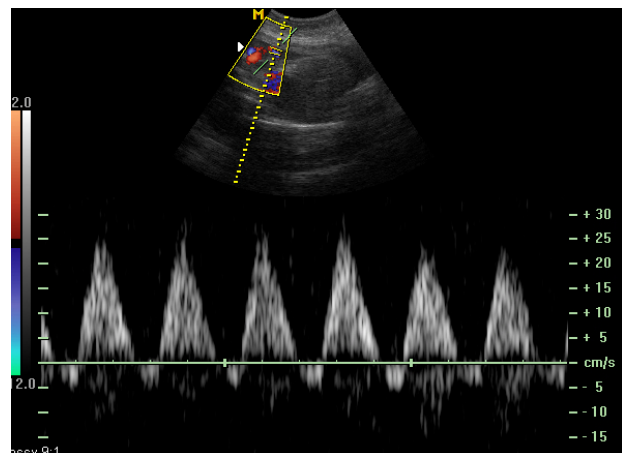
RF at umbilical artery Doppler. The mother was 18 years old and had pregnancy-induced hypertension. The foetus was born prematurely at 30 weeks and was a stillbirth after induction of labour. The foetal weight at delivery was less than 1.5 kg.
